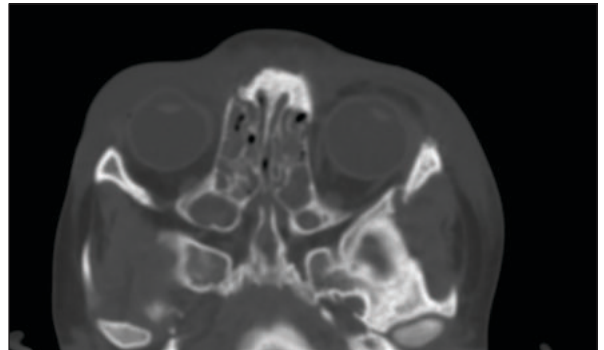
Axial CT Image Showing Segmental Fracture Of Left Zygomatic Arch.
